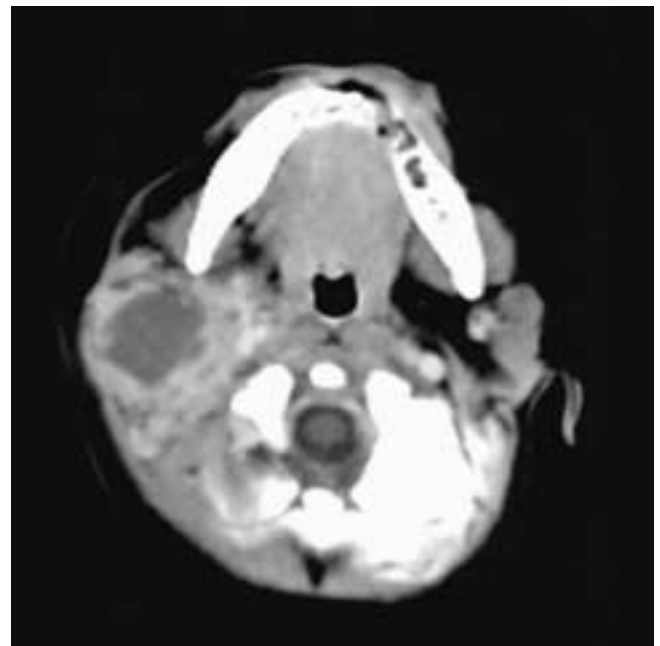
Axial contrast-enhanced CT scan on a child shows a large right parotid abscess. This child had been severely dehydrated prior to developing this abscess.
